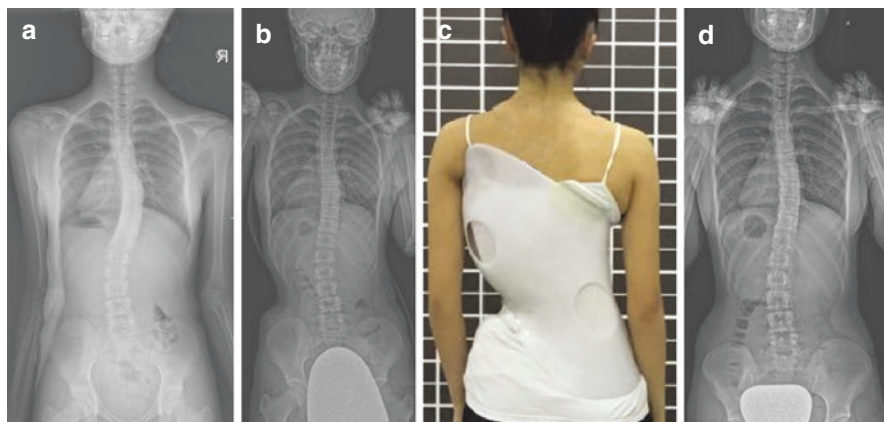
(a) A 11-year and 8-month-old patient was diagnosed with adolescent idiopathic scoliosis with curves measuring 30° in the main thoracic and 25° in the thoracolumbar areas. Brace treatment with asymmetric dynamic Rigo-Cheneau Brace was initiated along with Schroth exercises. (b) Both curves were measured as 15° in the in-brace radiographs taken 3 weeks after first fitting. (c) Good elongation and midline alignment were achieved and breathing mechanics were observed to well function clinically. The brace was renewed twice as the patient overgrew her brace. (d) Three and a half years later, radiographs displayed two balanced curves measuring 20° in the main thoracic and 15° in the thoracolumbar area with good midline alignment
